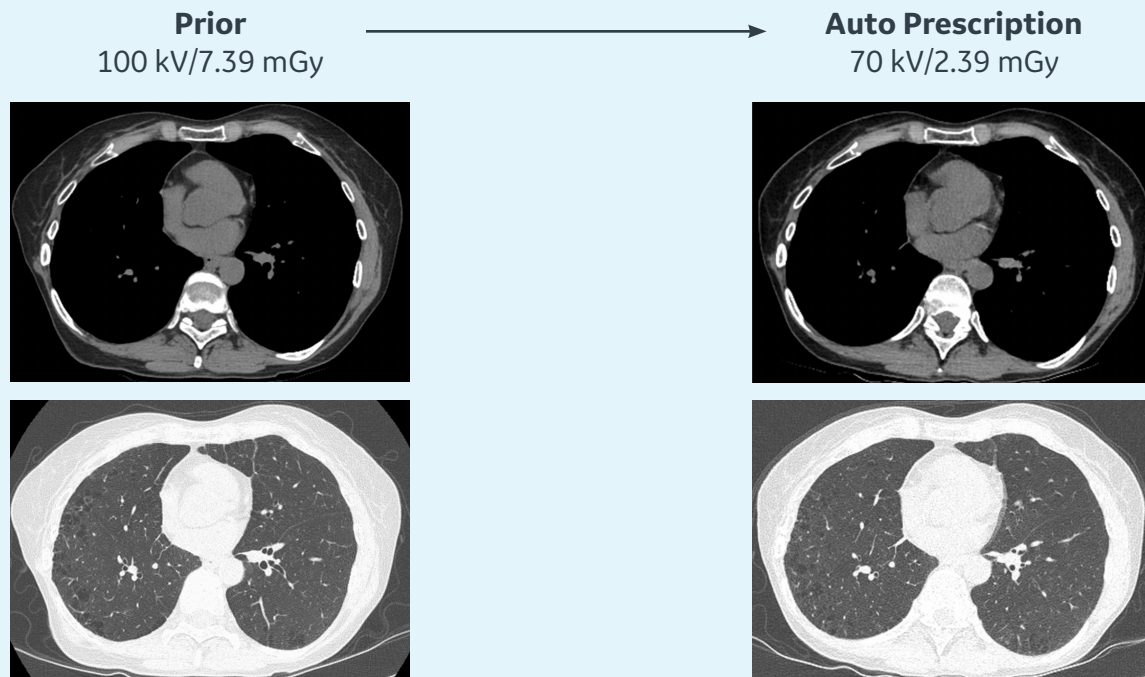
Same patient scanned on Revolution CT at 100 kV/7.39 mGy without Auto Prescription and at 70 kV/2.4 mGy with Auto Prescription (GE Thorax Profile). Both images were reviewed by a radiologist and rated above acceptable image quality. Reconstructions were performed using DLIR-M (top) and ASiR-V 0 (bottom).
